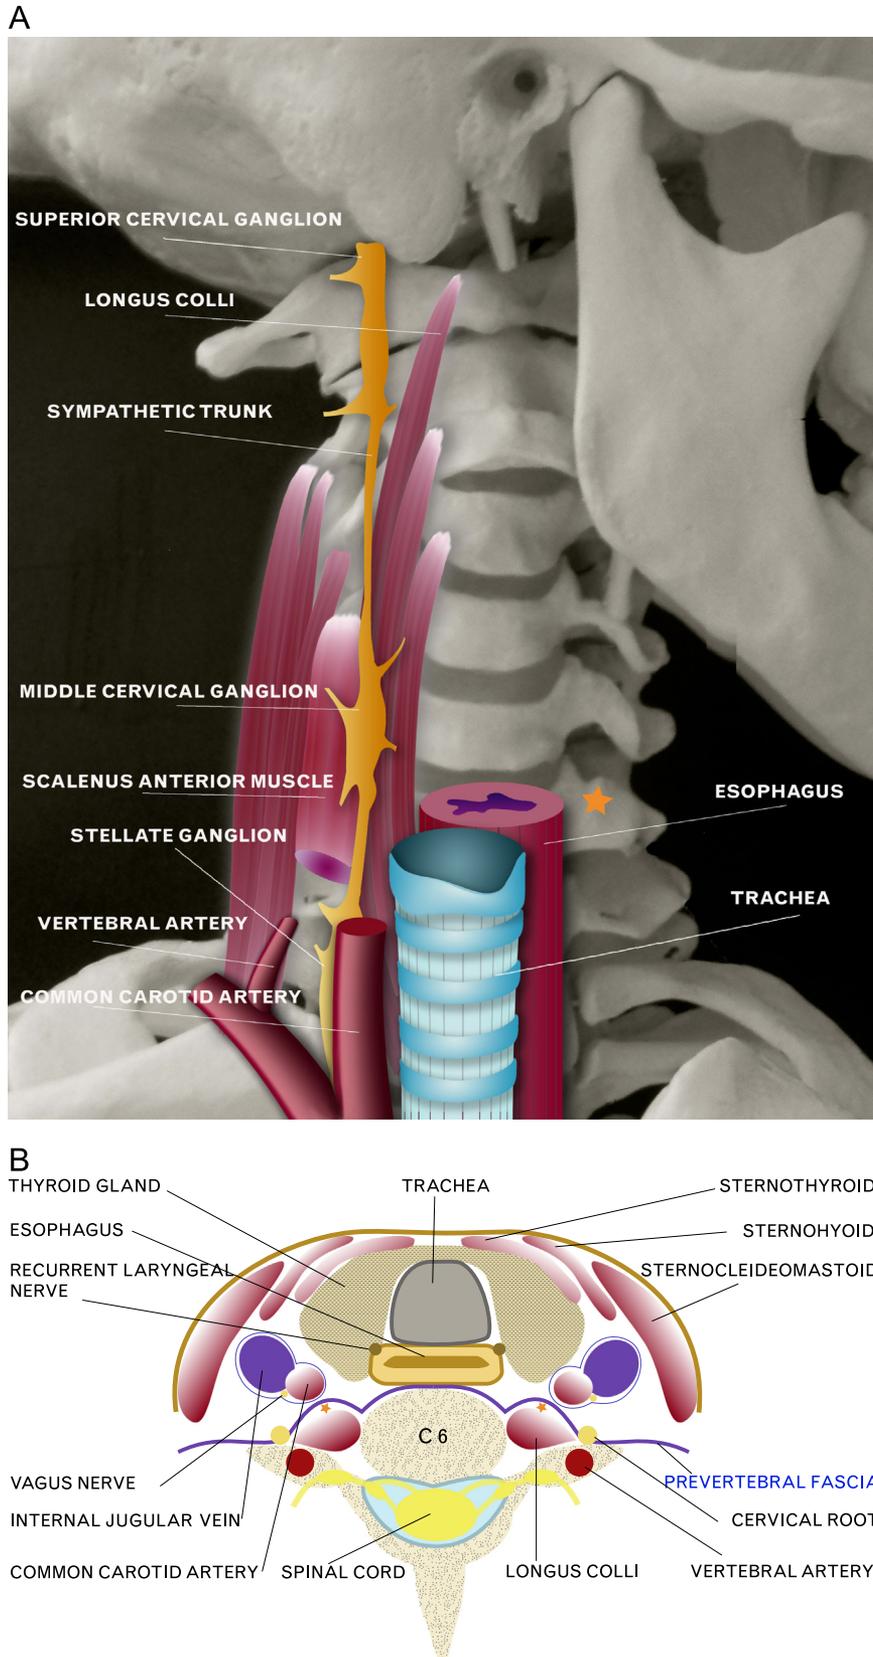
(A) Prevertebral region of the neck. The target site for the classical approach to the stellate ganglion is marked as orange star. (B) Cross-section of the neck at the sixth cervical vertebra level. The target site for ultrasound-guided stellate ganglion block is marked as orange star under the prevertebral fascia. (Color version of figure is available online.)
